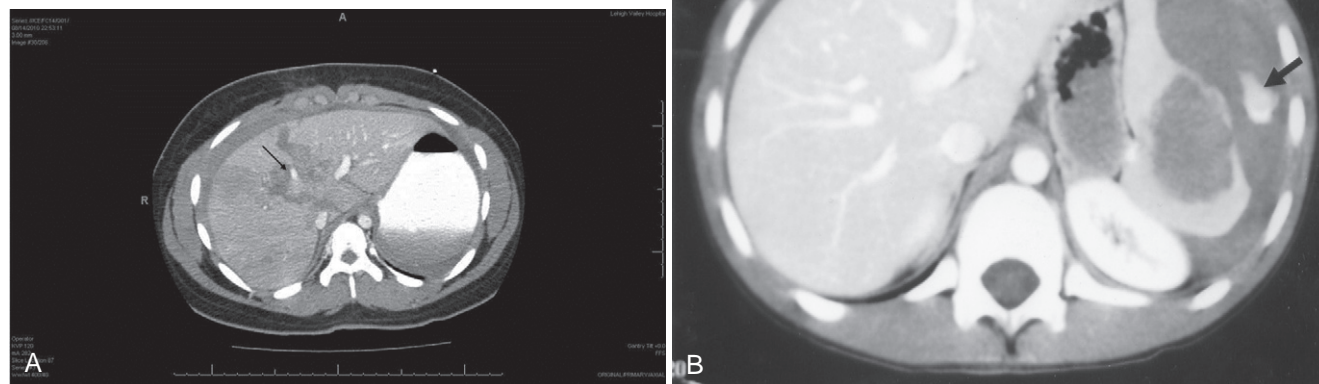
A, Abdominal computed tomography scan demonstrating a significant injury to the right hepatic lobe with intravenous contrast “blush” (arrow). This patient had successful angiographic embolization and avoided operation. B, Abdominal computed tomography scan demonstrating a significant injury to the spleen with intravenous contrast blush (arrow). The patient remained hemodynamically stable and avoided operation.
